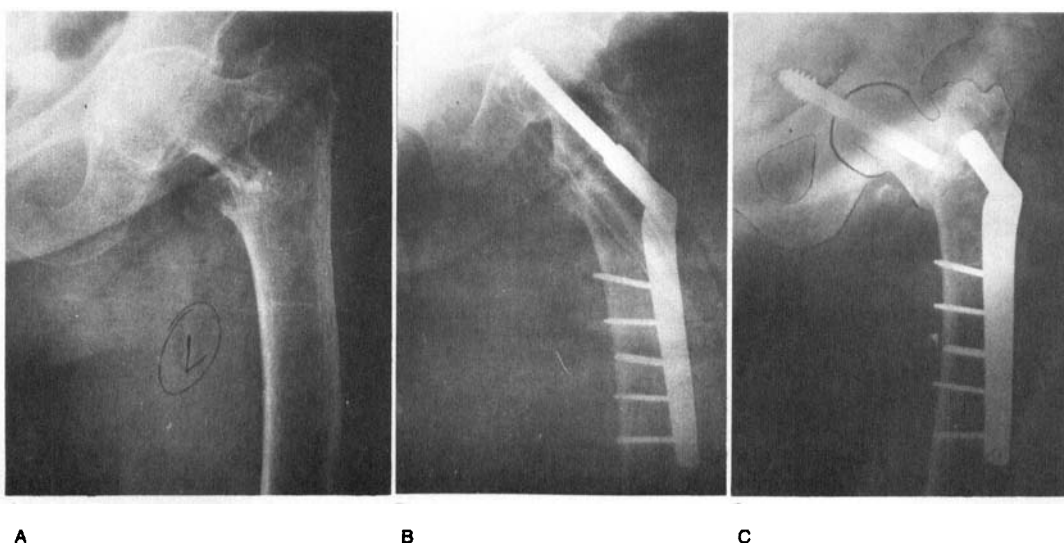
Anteroposterior roentgenograms of the left hip.
